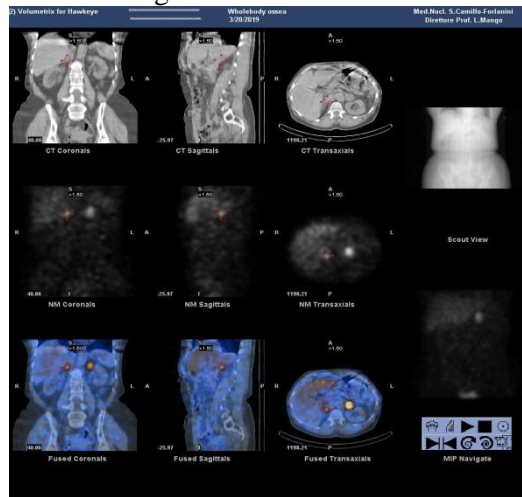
Abdomen SPECT/CT acquisition 24h after MIBG administration
